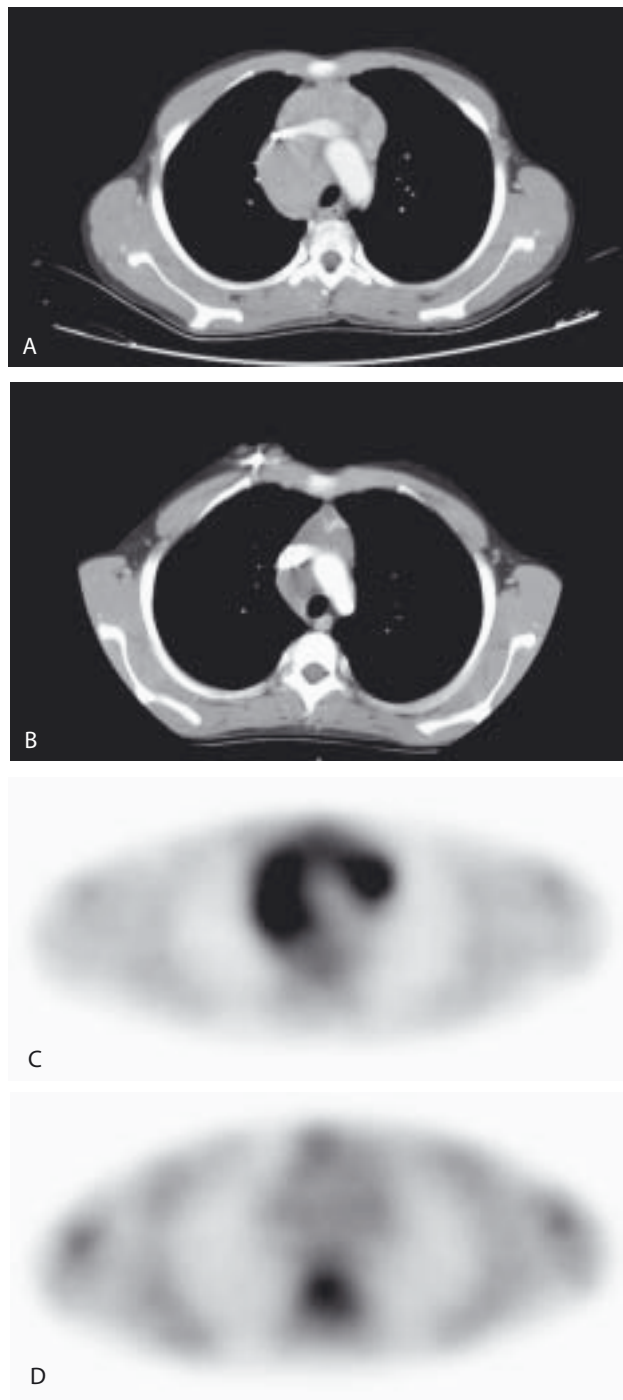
A 14-year-old boy with stage IIIB nodular sclerosing HD. A: Extensive mediastinal lymphadenopathy is present on the pretreatment CT scan. B: There is residual lymphadenopathy on the posttreatment CT scan, and it is not possible to differentiate persistent disease from fibrosis. C: There is extensive metabolically active disease on the pretreatment PET scan. D: There is complete resolution of the mediastinal activity on the posttreatment PET scan, however, confirming that the residual adenopathy present on the post-treatment CT scan did not contain viable tumor.
